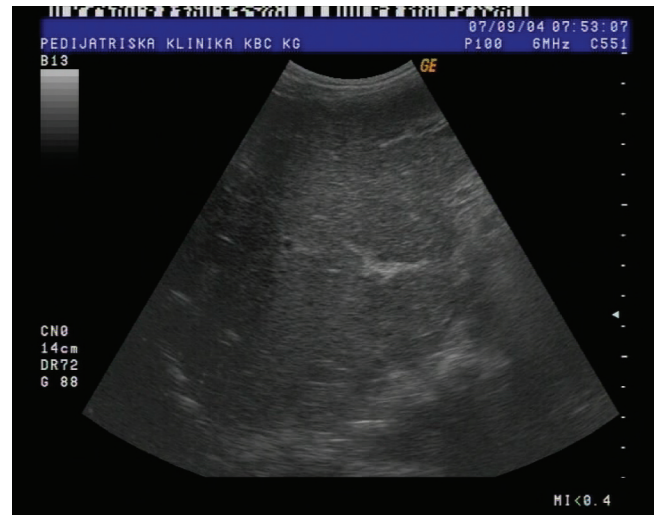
Ultrasound of irregular hepatic structure.
